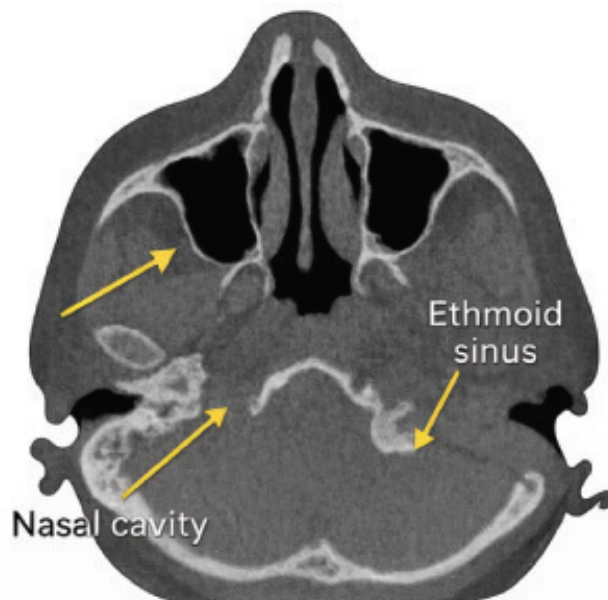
Axial computed tomography scan of the paranasal sinuses demonstrating mucosal thickening and partial opacification of the bilateral maxillary and ethmoid sinuses with narrowing of the nasal cavity. These findings are consistent with chronic rhinosinusitis and possible Eustachian tube dysfunction, which may contribute to auditory and vestibular symptoms.
